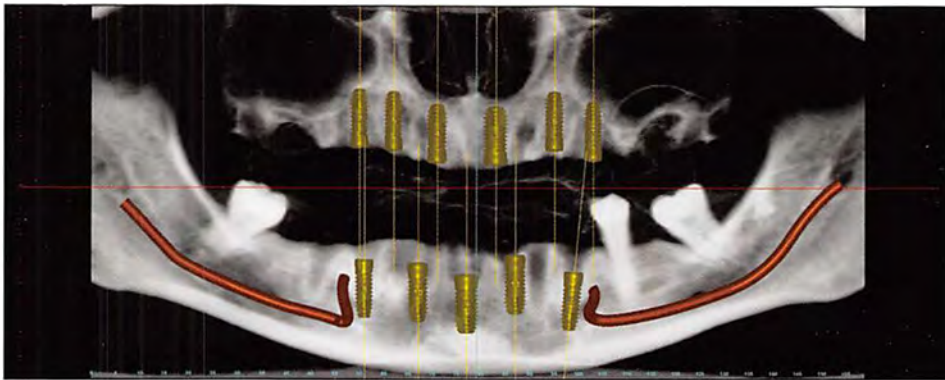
CT scan, panoramic view, showing implant positions for maxillary and mandibular zirconia, implant-supported, screw-retained bridges.
